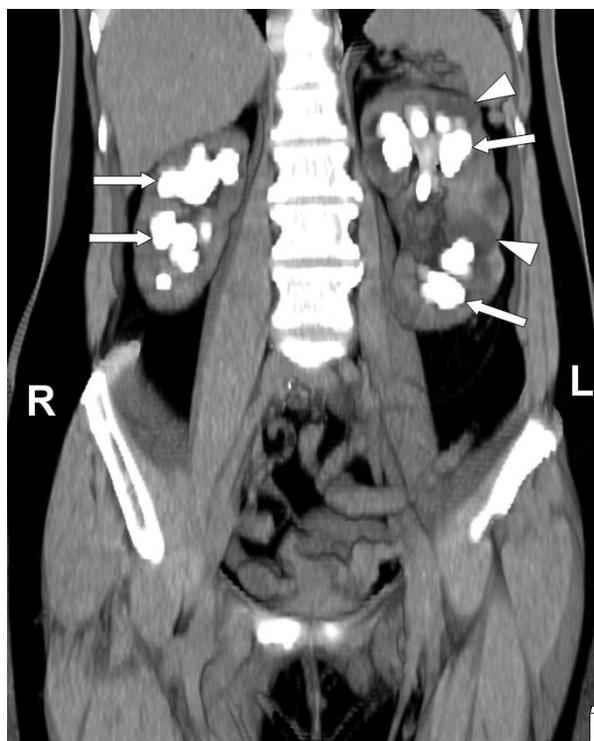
Bilateral *staghorn* calculi in a 50 year old female patient with recurrent urinary tract infection. Coronal maximum intensity projection non-contrast CT scan image shows calculi filling the renal calices (arrows). Dilated calices are also present in the left kidney (arrowheads).
